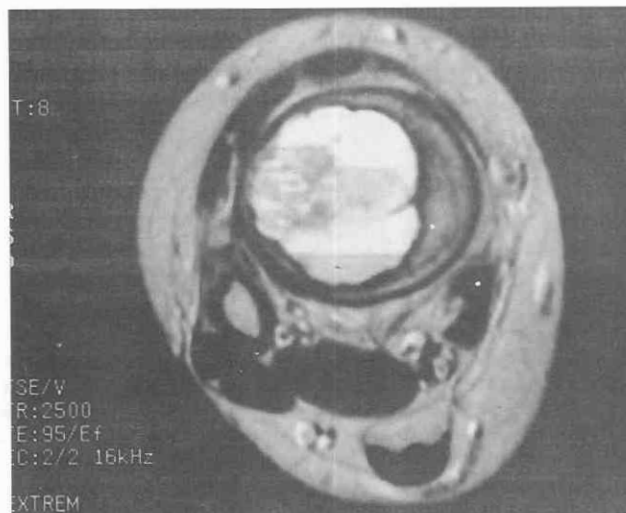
Aneurysmal bone cyst of the distal femur in a 10-year-old boy. Axial T2-weighted image (TR = 2500, TE = 95) without fat saturation shows multiple fluid-fluid levels within the lesion.
